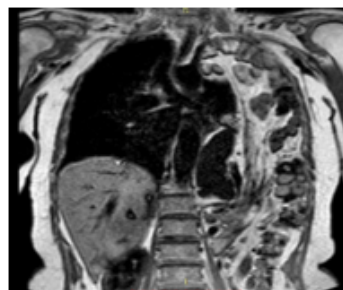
MRI of the patient showing herniation of bowel loops along the diaphragmatic defect in to the left hemithorax.
